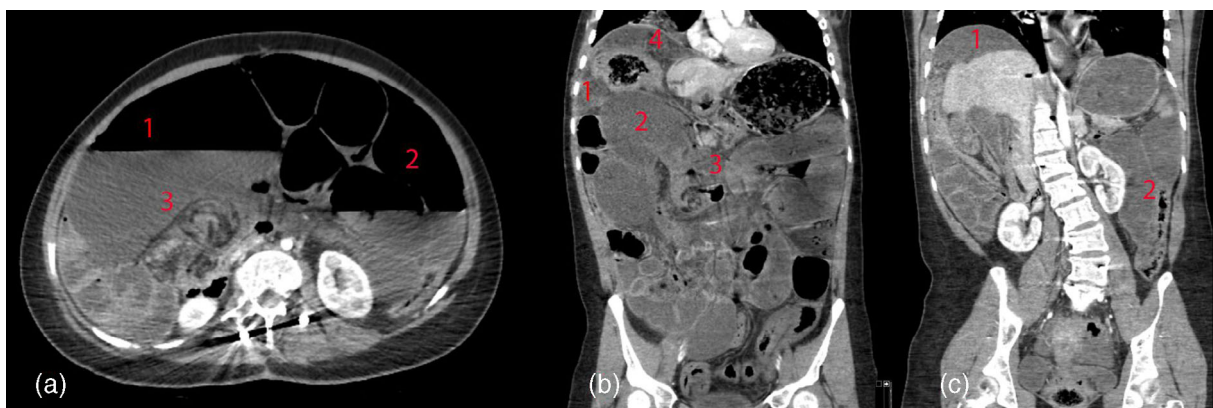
Case 1—CT imaging studies. (1) Free intraperitoneal air and fluid; (2) distended bowel; (3) whirl sign/mesenteric rotation; and (4) Chilaiditi sign
